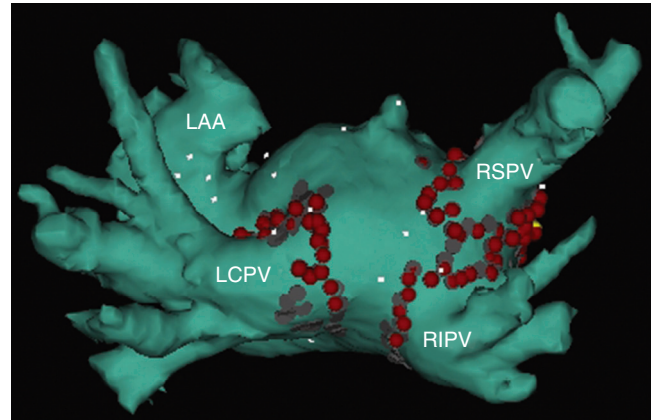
■ Three-dimensional electroanatomic map of the left atrium showing integrated information from intracardiac mapping and a previously acquired computed tomography image (CartoMerge, Biosense Webster, Inc.). This patient has a left common pulmonary vein (LCPV) that gives rise to superior and inferior branches, and separate right-sided pulmonary veins. The red and gray circles indicate sites of ablation performed in a circumferential pattern around the pulmonary veins. Bidirectional electrical isolation of all pulmonary veins without additional ablation lines was performed in this patient. LAA, Left atrial appendage; RIPV, right inferior pulmonary vein; RSPV, right superior pulmonary vein.
